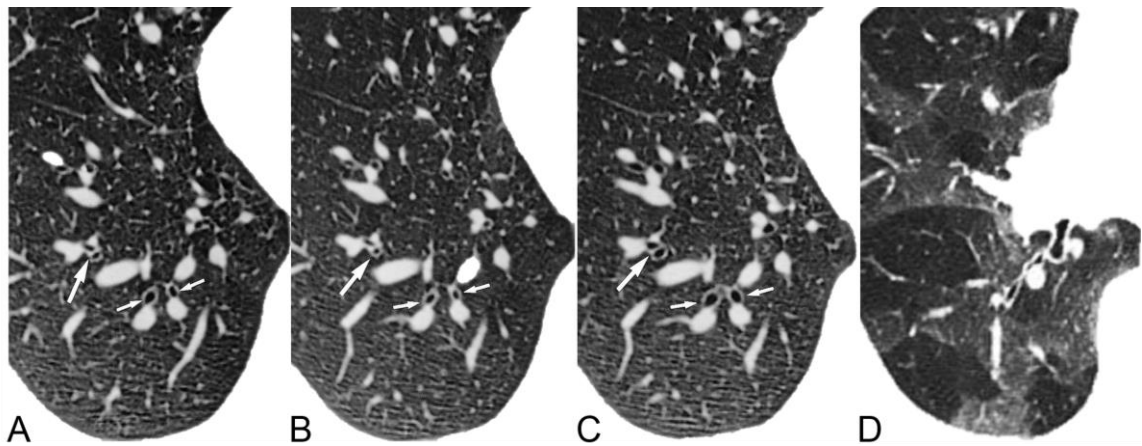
Axial CT of the right lower lobe in two representative asthmatics.
